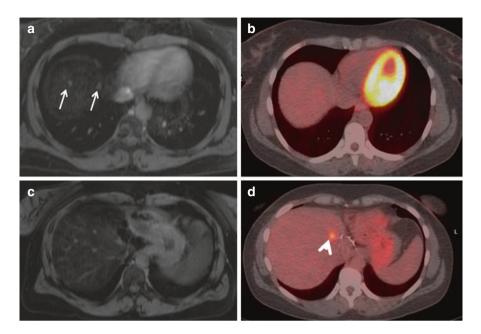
Role of PET-CT in hepatic metastases. 37-year-old woman with colon cancer. Past history of hemicolectomy followed by left hemihepatectomy for liver metastases 7 months later. Follow up MRI done 5 months after hepatectomy demonstrates two subtle focal lesions consistent with metastases at the hepatic dome on the fat suppressed T2 images (arrows in a). Fused PET-CT failed to demonstrate the two sub cm lesions at the dome (c) but demonstrated a focal high intensity uptake at the resection margin (arrow head in d) in keeping with recurrent disease. This was however not seen on MRI likely secondary to metallic artefacts. Artefacts form the surgical staples can make MR assessment difficult; while smaller lesions can be below the sensitivity of PET-CT thus emphasising the complimentary role of the two modalities for complete assessment of the liver
